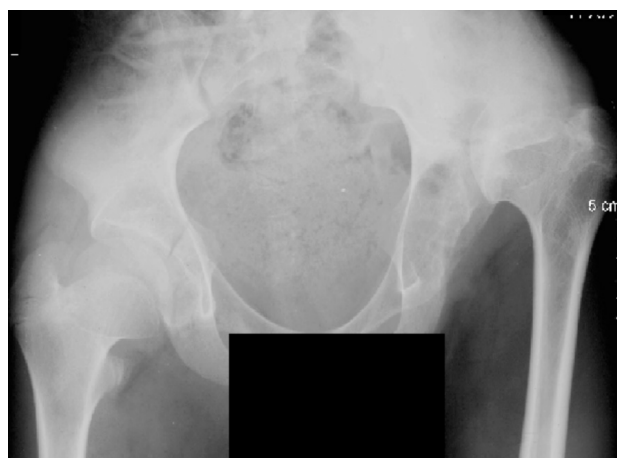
Anteroposterior pelvis radiograph showed drastic unilateral hip dislocation and shortened femoral necks.
